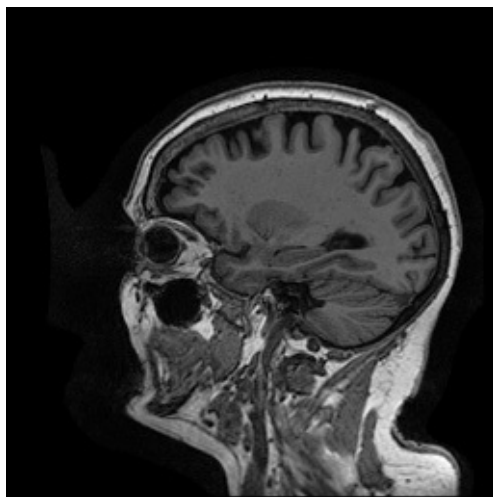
structural MRI image of Cognitively Normal (from the dataset ADNI1-Annual-2-Yr-3T-8-03 2019)
